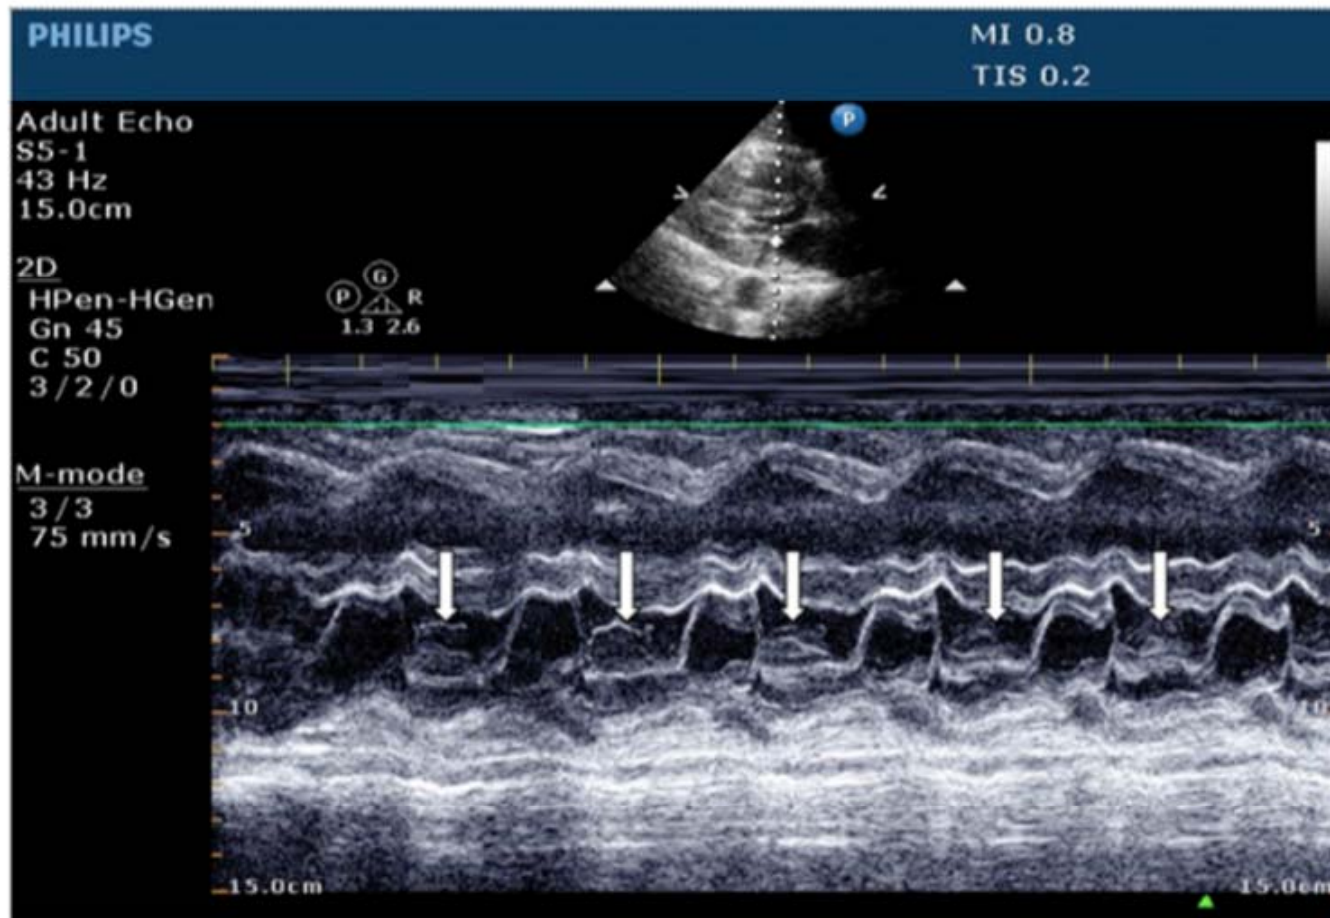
M-mode echocardiography. The *arrows* indicate systolic anterior motion of mitral leaflet during systole, which narrows the left ventricular outflow tract.
